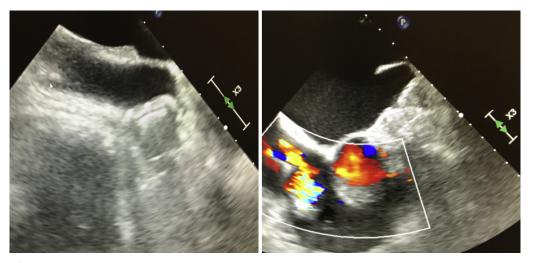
Transesophageal echocardiogram showing a well-seated WATCHMAN device without a device thrombus.
